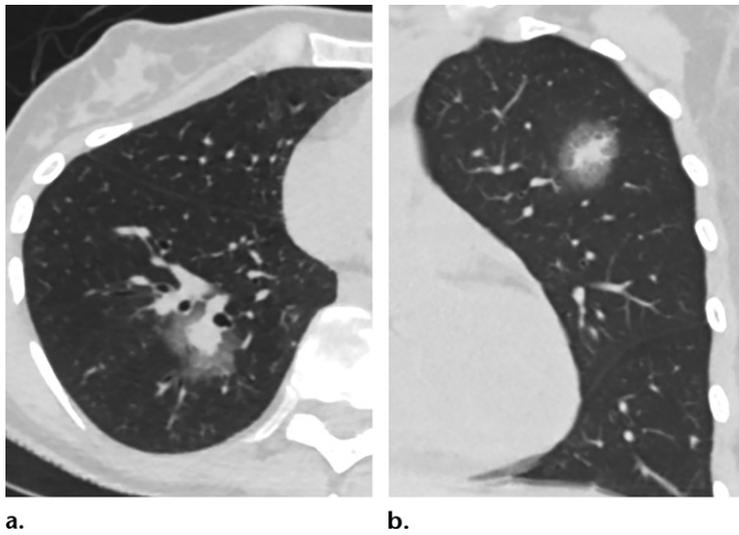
CT halo sign. Axial CT image in a patient with IPA (a) and coronal CT image in a patient with PM (b) depict a central solid nodule surrounded by an area of ground-glass opacity.
